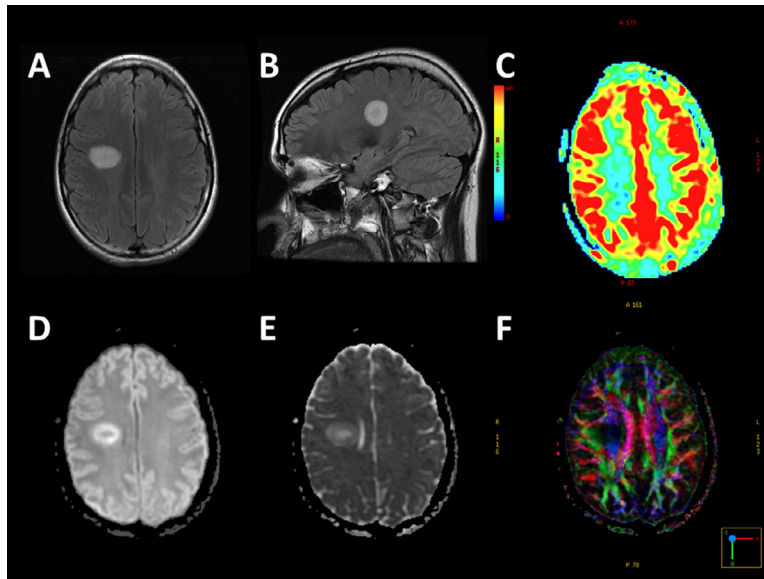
Magnetic resonance imaging of Balo concentric sclerosis. (A) Axial and (B) sagittal T2-weighted FLAIR images show typical multilayered concentric ring lesion in the right centrum semiovale. (C) Cerebral blood flow map shows regional hypoperfusion with central minimally increased perfusion within the lesion. (D) Isotropic combined diffusion-weighted image and mean diffusivity map show a ring of relatively reduced diffusion along the rim of the lesion. (E) Directionally-encoded color fractional anisotropy map shows near-complete loss of normal white matter anisotropy in the region of right corticospinal tract.
